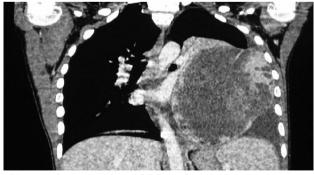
Coronal section of CT Scan Chest with contrast showing a large tumor mass lesion causing shifting of the mediastinum towards right side.
